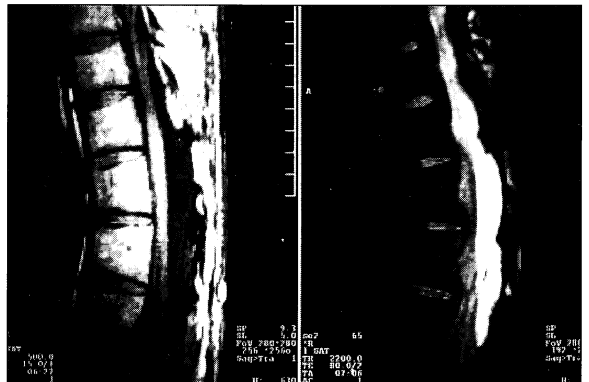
Sagittal T1-weighted image showing a low signal lesion at the thoracolumbar junction posteriorly. The T2-weighted scan shows high signal intensity indicating a cystic lesion
